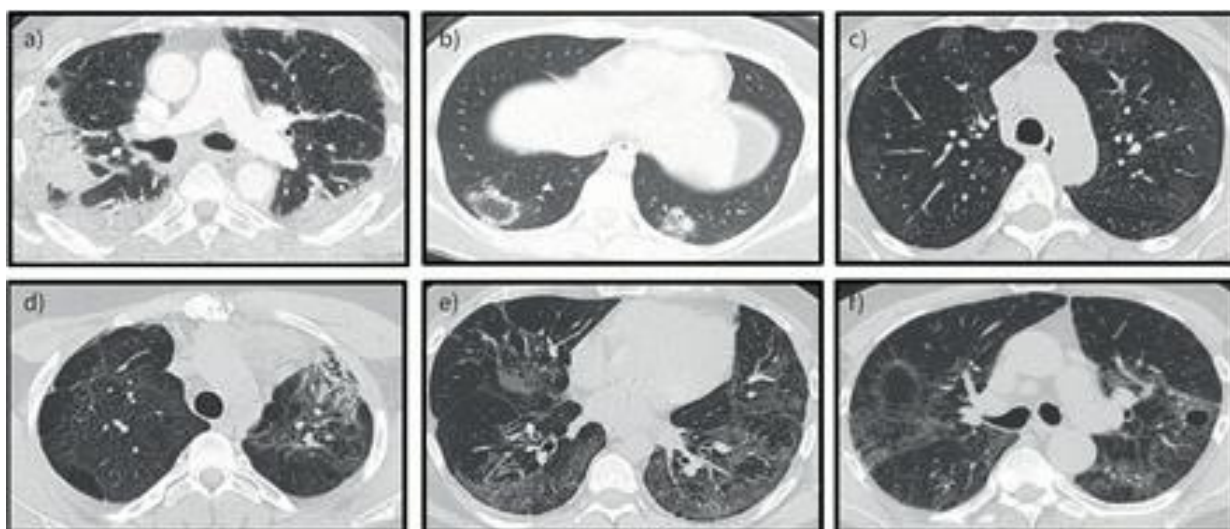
Representative CT scan findings (a) dense consolidations, (b) patchy consolidation and ground-glass opacities with an atoll sign, (c) diffuse ground-glass opacities, (d) fibrosis with honeycomb
